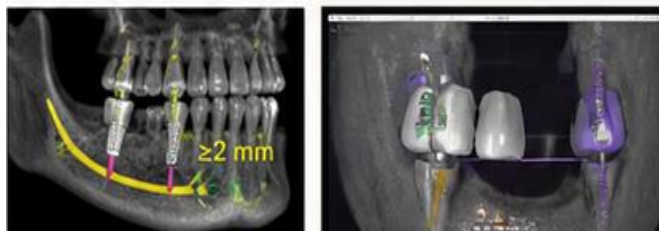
Thorough preoperative planning with CBCT evolution
